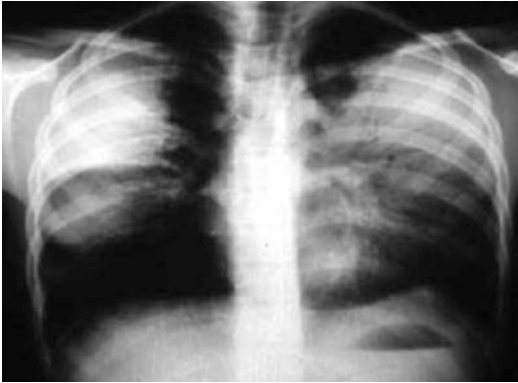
Alveolar pneumonia. Chest X-ray of 6-year-old schoolchild presenting with an extensive bilateral lobar consolidation (similar to that caused by *Streptococcus pneumoniae*)
